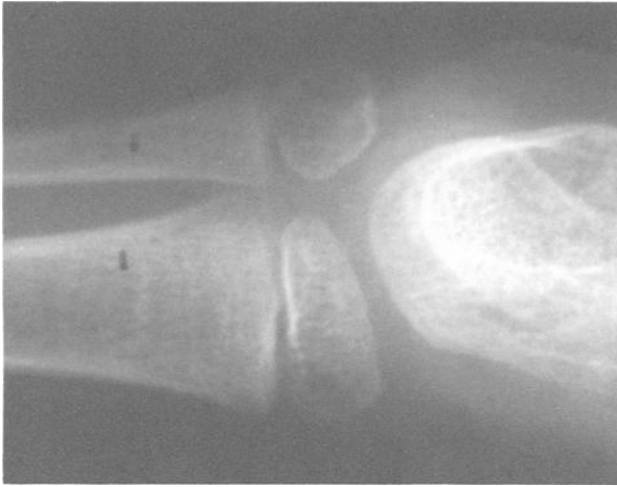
X-radiograph of the distal tibia and fibula.*
